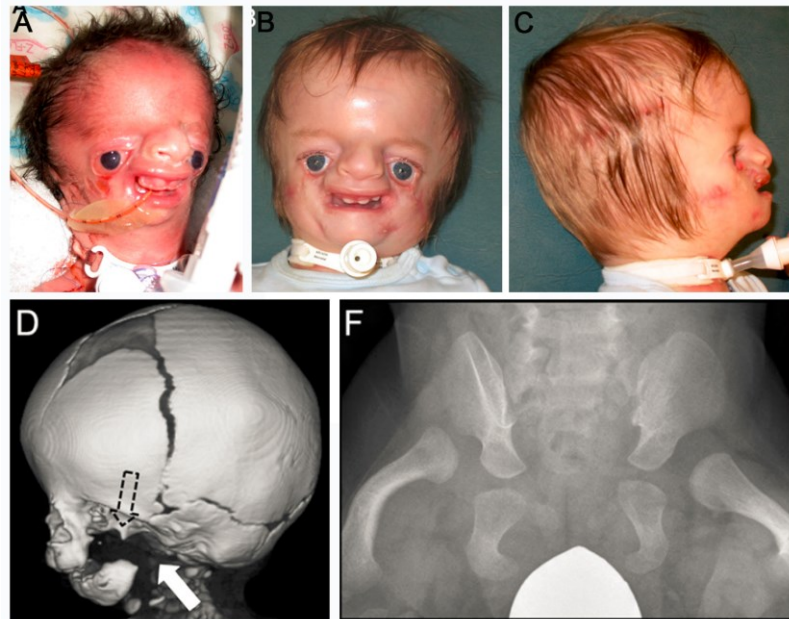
1 Affected individual 1 displays multiple craniofacial anomalies. A) Individual 1 at birth showing severe craniofacial anomalies. B,C) Individual 1 at 18 months after reconstructive surgeries. D) 3D CT image showing severe hypoplasia of the zygomatic and maxillae (dashed arrow) as well as retrognathia (white arrow). F) X-ray showing hip dysplasia and bowed femurs. Figure adapted from Weaver, Watt, *et al.*, 2015.
